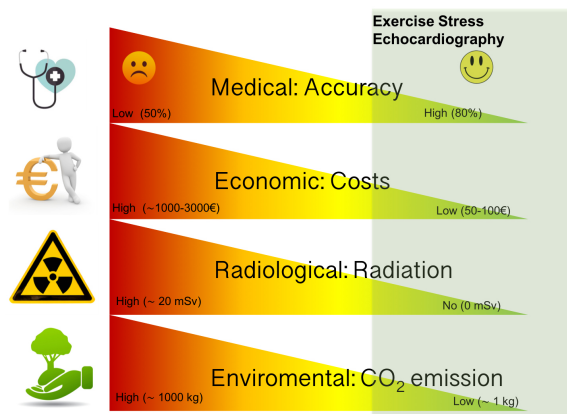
The dimensions of sustainability in ESE. Like all imaging modalities, exercise stress echocardiography can be categorized in a system with different dimensions including diagnostic/prognostic accuracy from physician perspective, economic/costs from payer perspective, radiation exposure from patient perspective, environmental footprint, from planet perspective. The green area subtended supports a leading and current role of exercise stress echocardiography in patients with stable coronary artery disease. CO₂, carbonic oxide; ESE, exercise stress echocardiography.
